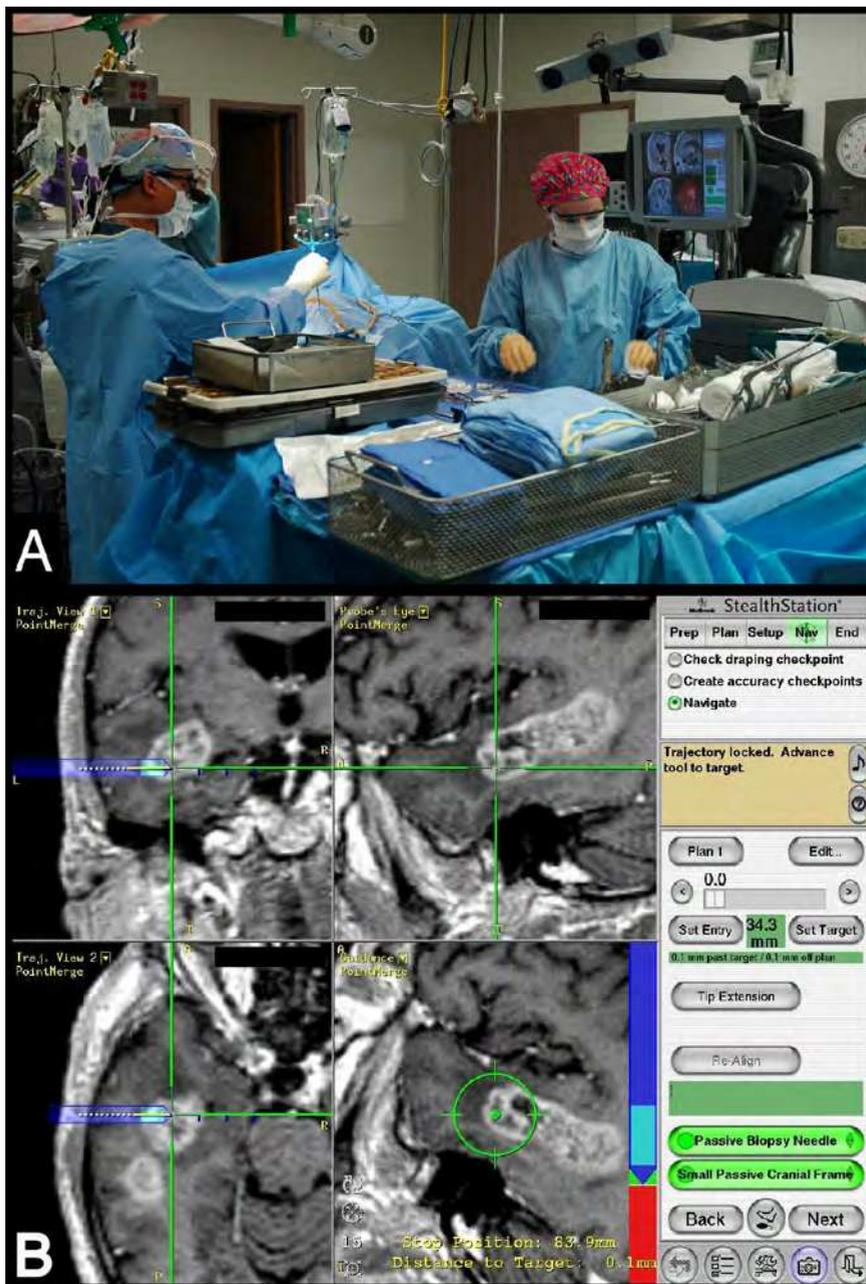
Neuronavigation. Operating room setup with patient positioned and neuronavigational stereotactic equipment (A). Neuronavigational MRI for stereotactic guided biopsy showing a temporal lobe glioma in three planes.
